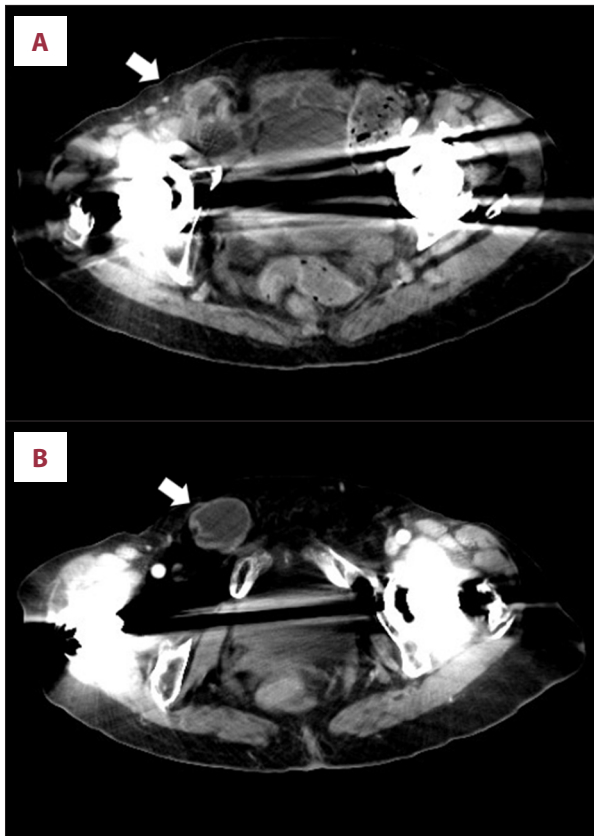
Contrast-enhanced axial computed tomography findings of the right inguinal hernia. (A) Small-bowel herniation at the internal inguinal ring (arrow). (B) Potentially incarcerated small bowel within the inguinal canal (arrow). (C) Mild localized proximal small-bowel dilatation.
